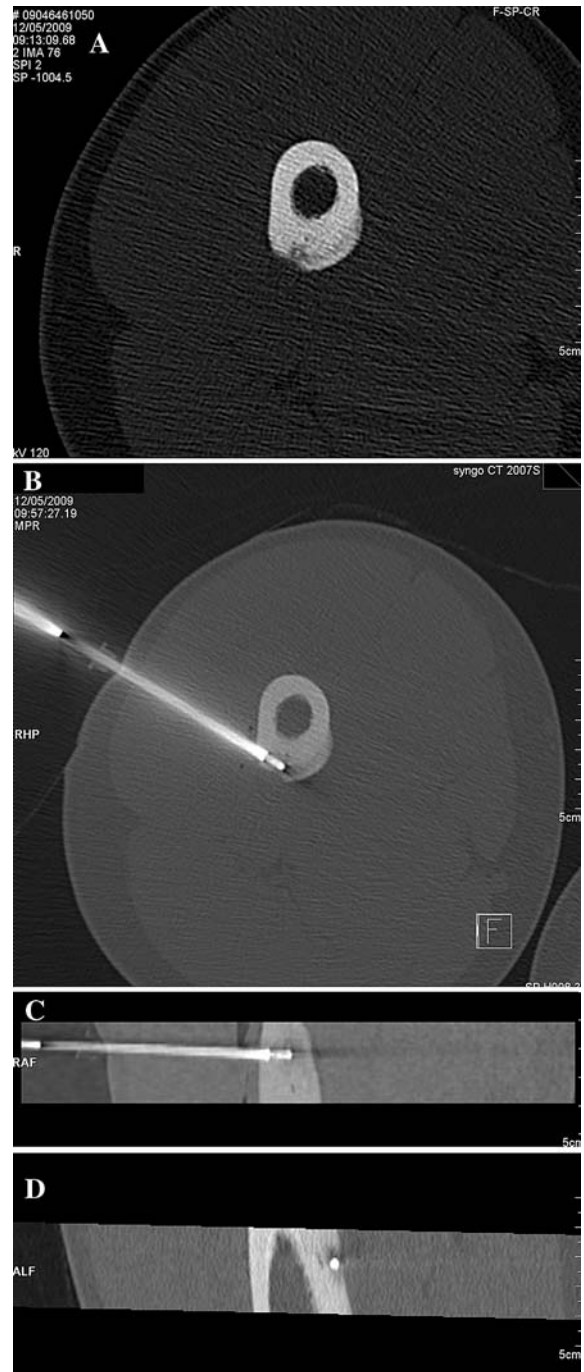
Example of percutaneous biopsy with the 12.5-gauge trephine needle introduced into the 11-gauge Laurane needle in a case of osteoid osteoma of the posterior cortex of the femoral diaphysis in a 19 year-old boy. A Axial CT image showing the small nidus with a central calcification into the posterior cortex of the femoral diaphysis. B Axial multiplanar CT reformation. C Coronal multiplanar CT reformation. D Sagittal multiplanar CT reformation. B–D show that the tip of the trephine needle is actually into the nidus in all three planes. In this case, a lateral approach was selected rather than a direct posterior approach to avoid the sciatic nerve
